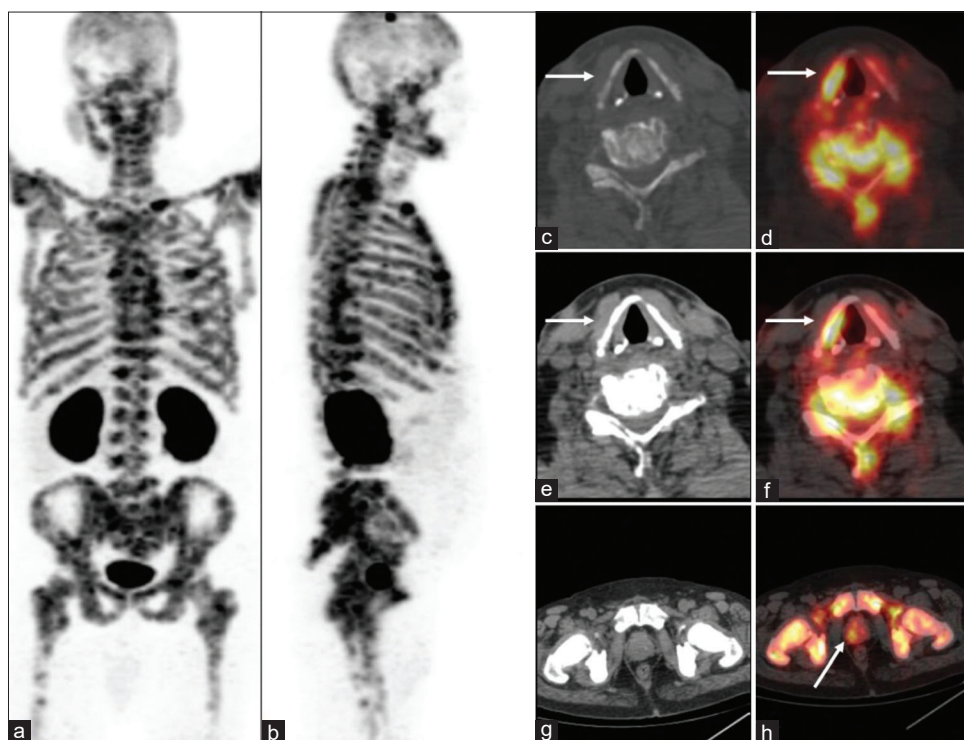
⁶⁸Ga-prostate-specific membrane antigen positron emission tomography/computed tomography scan, anterior and lateral maximal intensity projection (a and b) suggestive of multiple prostate-specific membrane antigen avid lesions. Axial computed tomography and fused positron emission tomography/computed tomography images (c-f) showing prostate-specific membrane antigen avid lesions in the thyroid cartilage and multiple prostate-specific membrane antigen avid sclerotic skeletal metastases. Axial computed tomography and fused positron emission tomography/computed tomography images (g and h) showing prostate-specific membrane antigen avid primary lesion in the prostate gland
